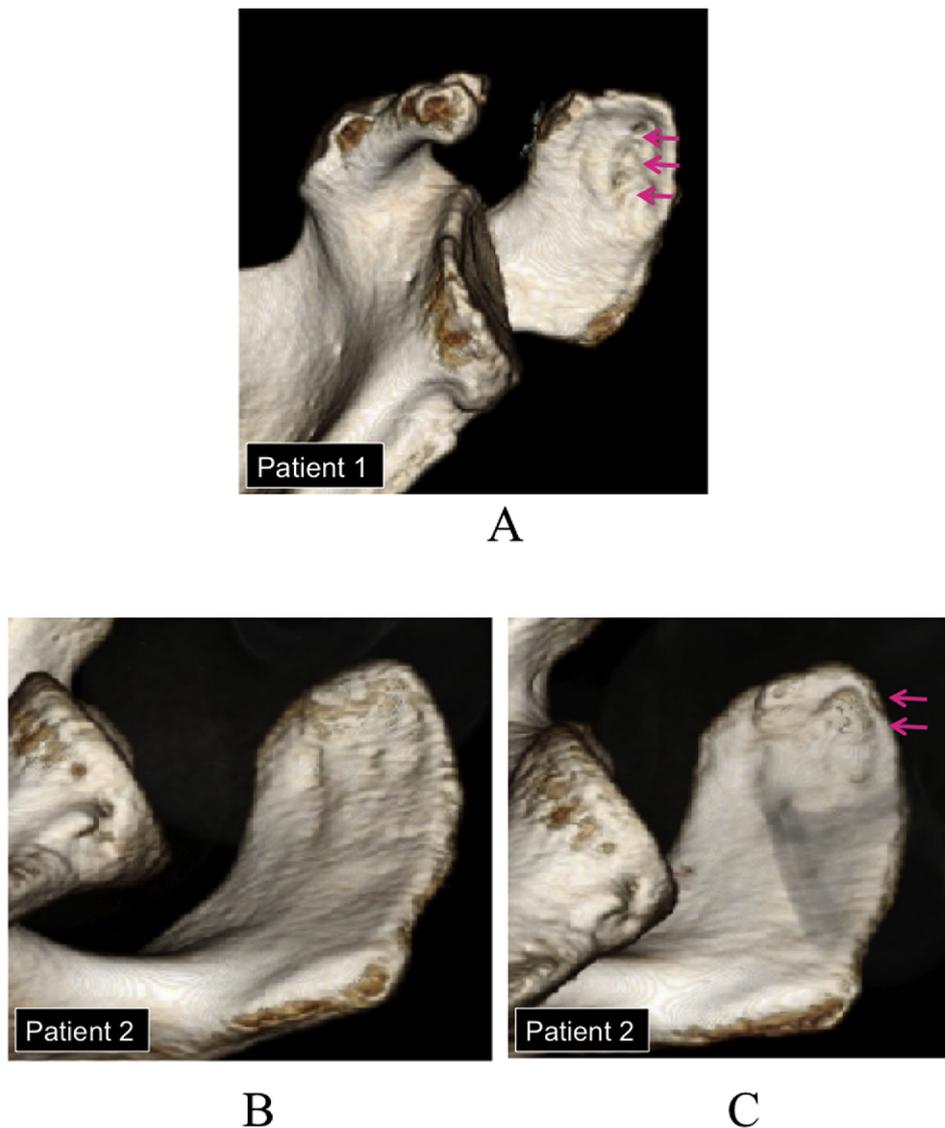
Three-dimensional computed tomography. (a) Subacromial bone erosion due to knot impingement 4 years after rotator cuff repair in patient 1. Pink arrows indicate bone erosion at the lateral side of the anterior half of the acromion. (b) No erosion was apparent 6 months after rotator cuff repair in patient 2. (c) Bone erosion (pink arrows) at the lateral side of the anterior half of the acromion was present 18 months after rotator cuff repair in patient 2.
